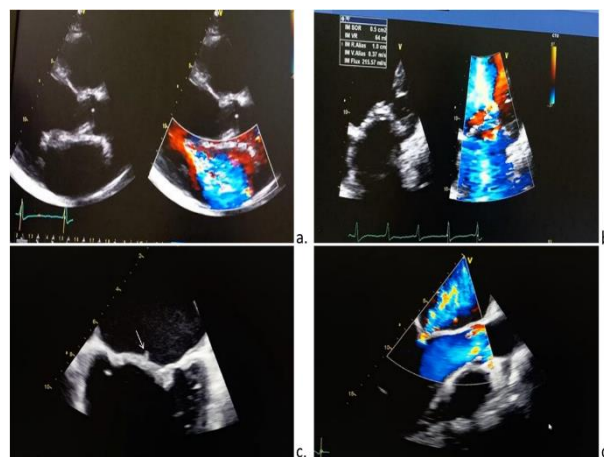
A and B, Transthoracic echocardiographic (TTE) images showing severe mitral regurgitation. C, Transesophageal echocardiography (TEE) image showing a 3-mm vegetation on the mitral valve (white arrow). D, TEE image showing mitral regurgitation extension
